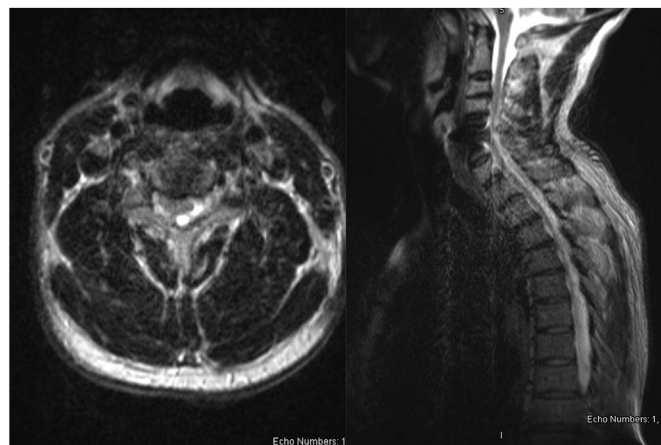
T2-weighted axial and sagittal magnetic resonance image of cervical and thoracic spine epidural abscess.
